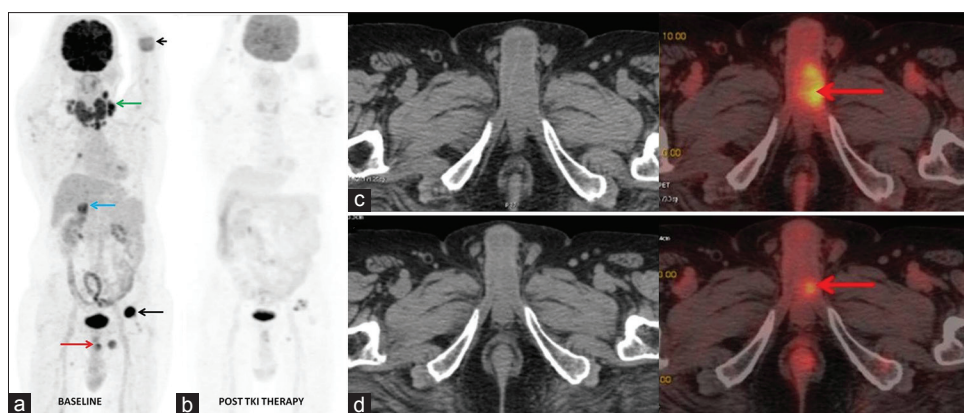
Positron emission tomography-computed tomography (a: maximum intensity projection) showed metastatic disease in cervical lymph nodes (green arrow), skeletal lesion in the left humerus (short black arrow), lesion in the left acetabulum (long black arrow), deposit in the left adrenal gland (blue arrow), and nodules in the bilateral lungs. In addition, an ill-defined, fluorodeoxyglucose-avid lesion was seen in the shaft of the penis causing deviation of septum to right (red arrow in a and c). Follow-up positron emission tomography-computed tomography after tyrosine kinase inhibitor therapy (maximum intensity projection: b) showed significant morphological and metabolic reduction in all previously seen lesions including penile lesion (red arrow d)
